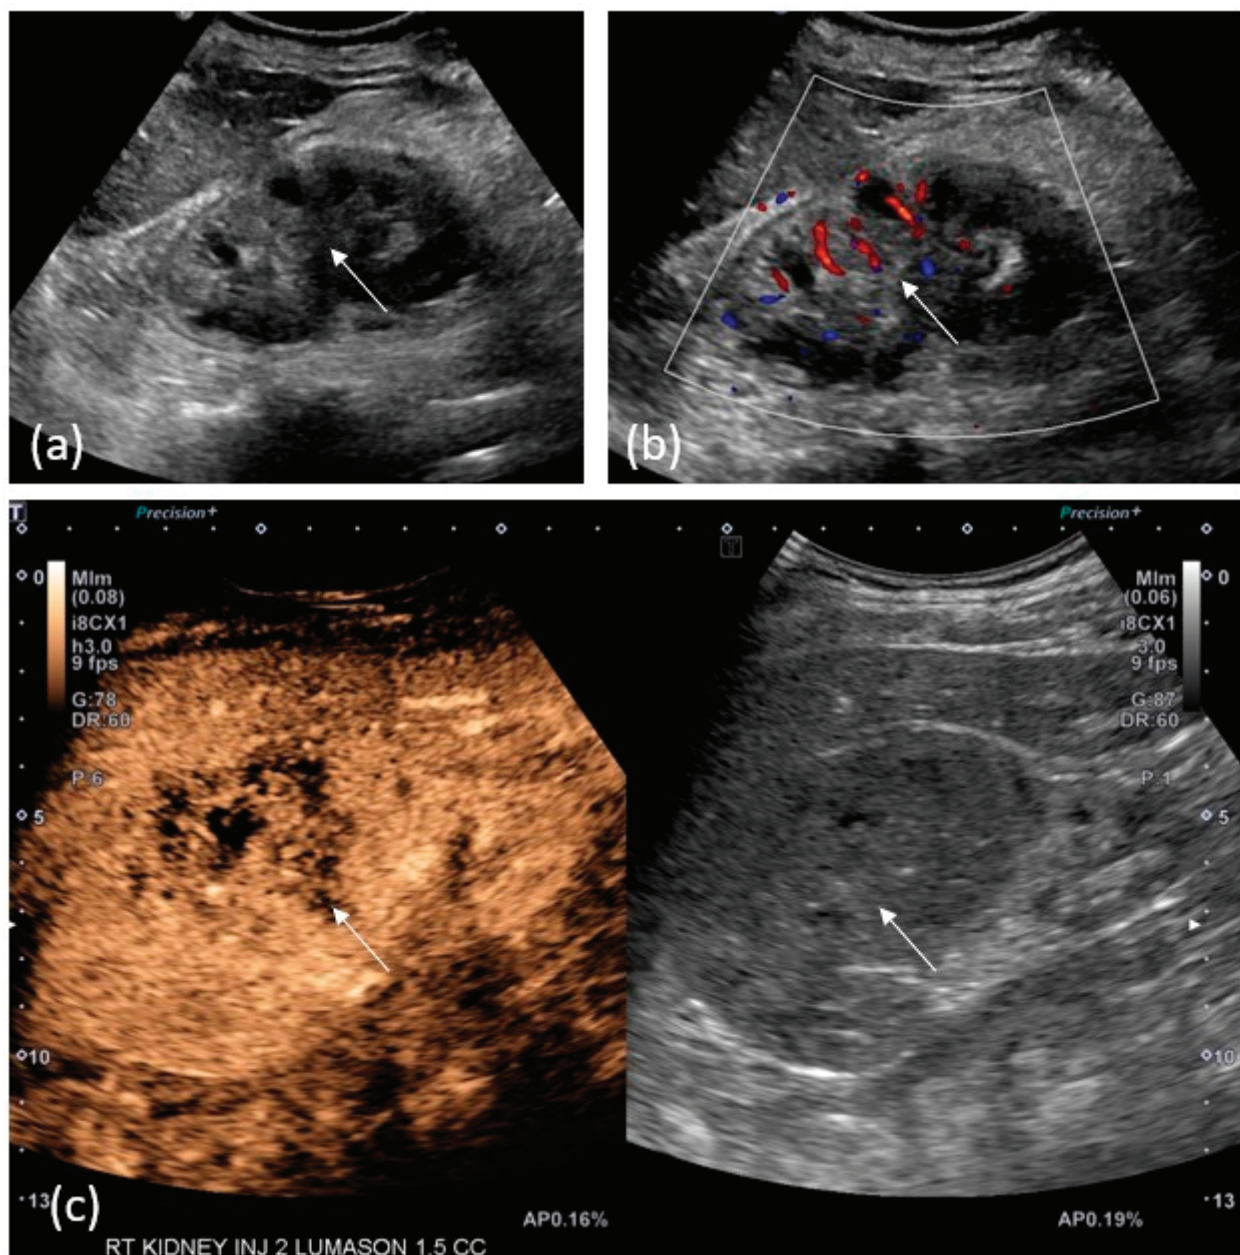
A 71-year-old-woman with right renal mass. (a) Grey-scale ultrasound image shows a mass-like hyperechoic area involving the renal pelvis. (b) Color Doppler reveals only mild vascularity. (c) After injection of 1.5 cc of Lumason, post-contrast images confirm a hypoechoic mass in that location.
